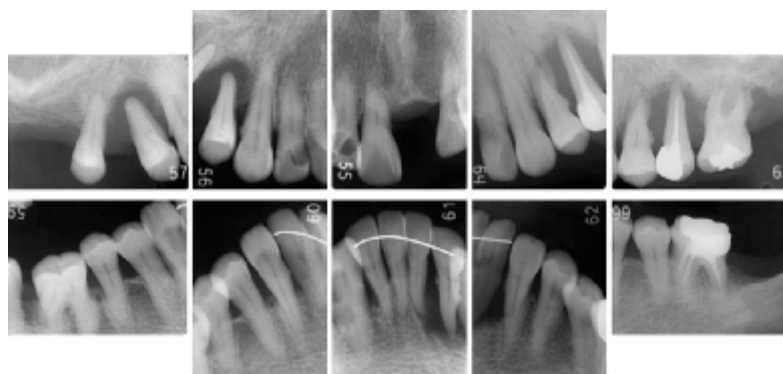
Dental radiographs at baseline: Generalized horizontal alveolar bone loss was observed. Extreme bone loss was prominent at the upper premolar with a "floating teeth" appearance. Advanced bone loss was also observed at the lower left incisor.
